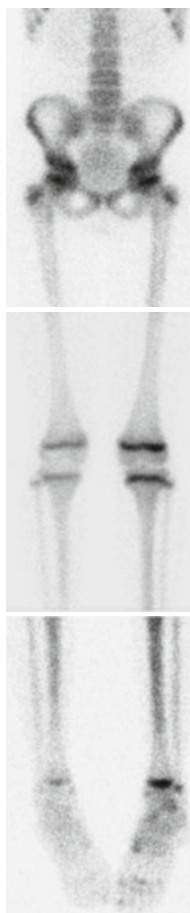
An 8-year-old female with right leg pain for a week after a fall with twisting of her right leg. MRI revealed no hip pathology. The patient was using crutches and did not put weight on her right leg. There is diffusely decreased uptake throughout the right lower extremity due to reduced overall flow with disuse. Conversely, the left leg that was supporting the patient's weight reveals relatively increased tracer uptake
